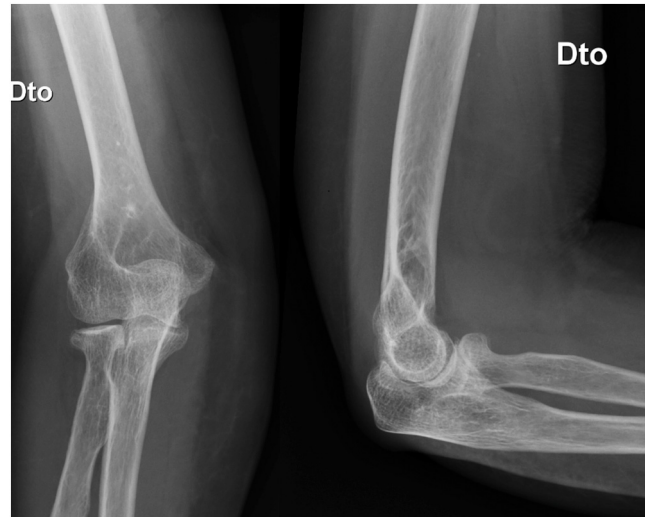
X-Ray at 18 months of follow-up, showing no signs of complications.
